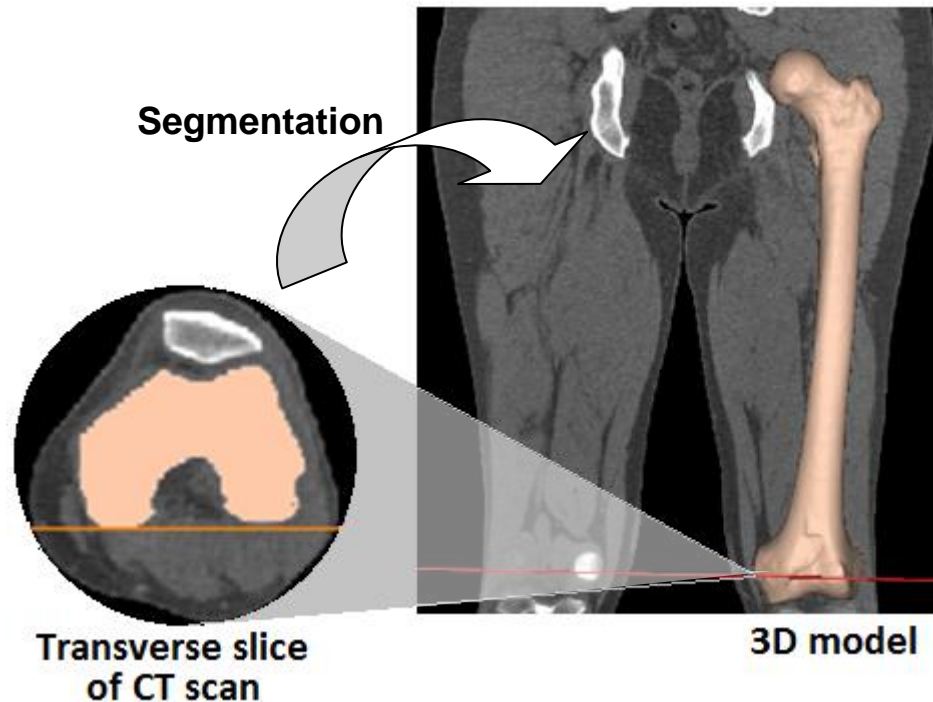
Three-dimensional model was generated by segmenting CT scans
